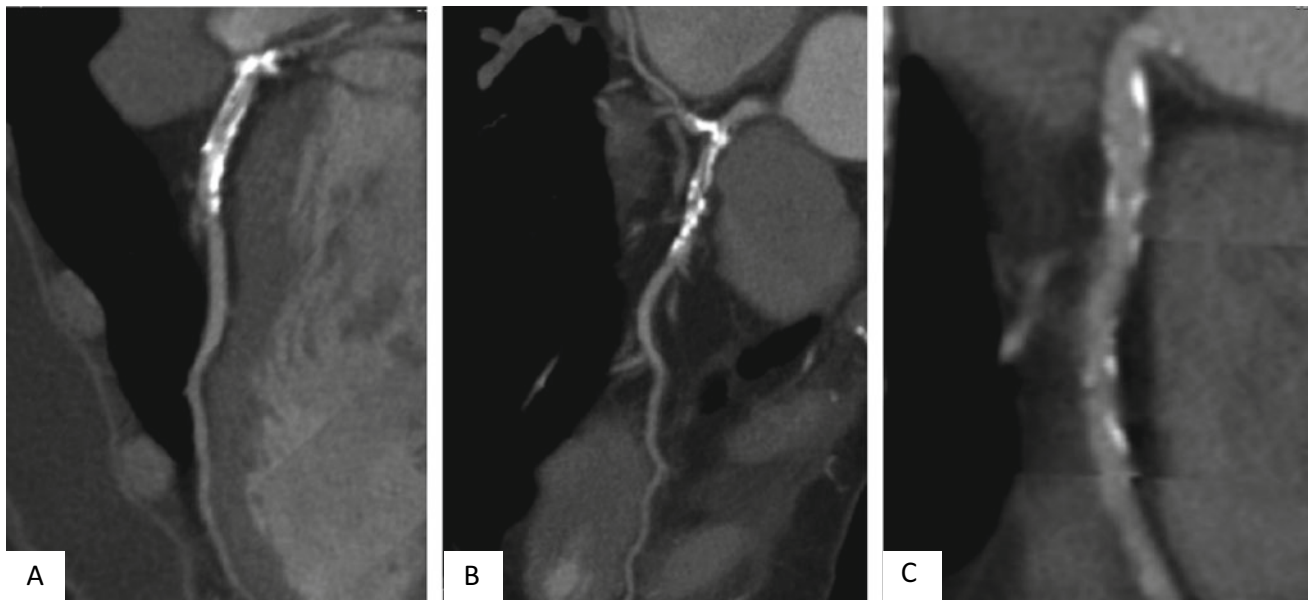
CT coronary angiogram. a and b show calcification in the proximal left anterior descending and left circumflex coronary arteries. c shows more diffuse calcification in the right coronary artery. The plaques were interpreted as non-obstructive
